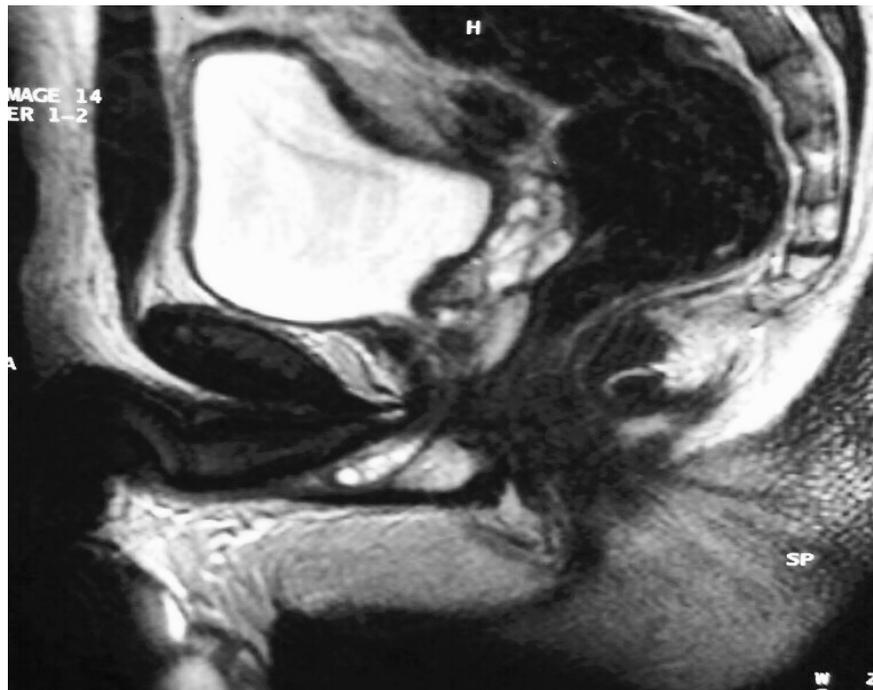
Pelvic MRI showing the prostatic urethra and the bladder neck
